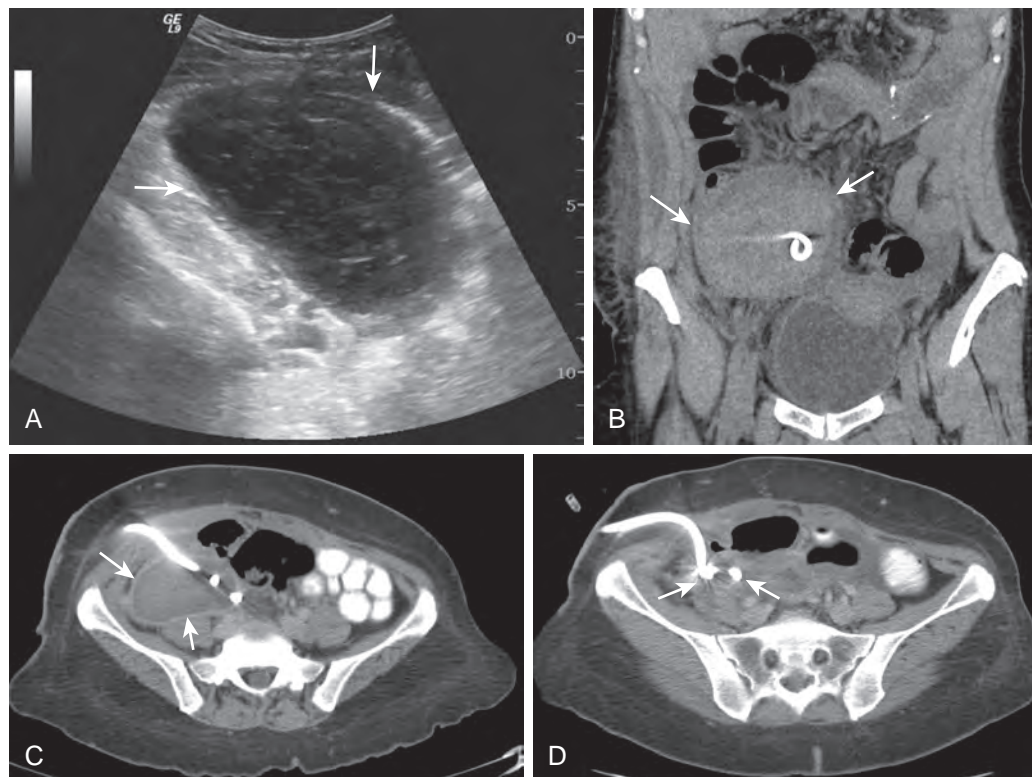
Thrombolytic therapy for effective abscess drainage. A. Transverse ultrasound image of a 67-year-old man with an intraperitoneal abscess shows multiple internal septations (arrows). Percutaneous abscess drainage was performed. B. CT obtained 2 weeks later shows persistent abscess despite adequate catheter positioning (arrows). High density of the internal contents of the abscess suggests viscous contents. tPA instillation was performed into the abscess. C. CT obtained after six doses of tPA showed improved liquefaction of the abscess contents (arrows). D. Follow-up CT obtained 1 week later showed complete collapse of the abscess cavity (arrows).
